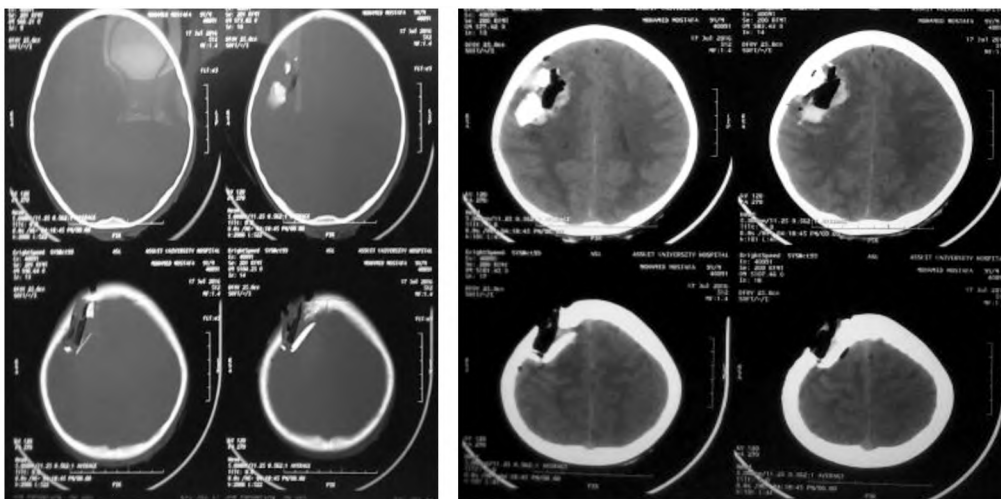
CT bone and soft tissue window shows right frontoparietal depressed fracture with hypodense foreign object intra-axial.
